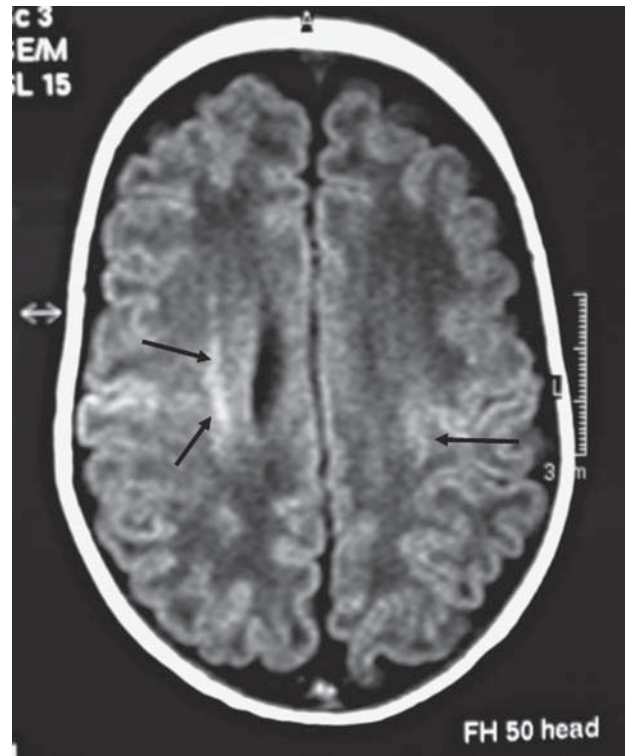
T1-weighted MRI at term equivalent age, axial plane of a preterm infant born at 27 weeks showing multiple small punctate lesions (arrows) beside the corona radiata.
